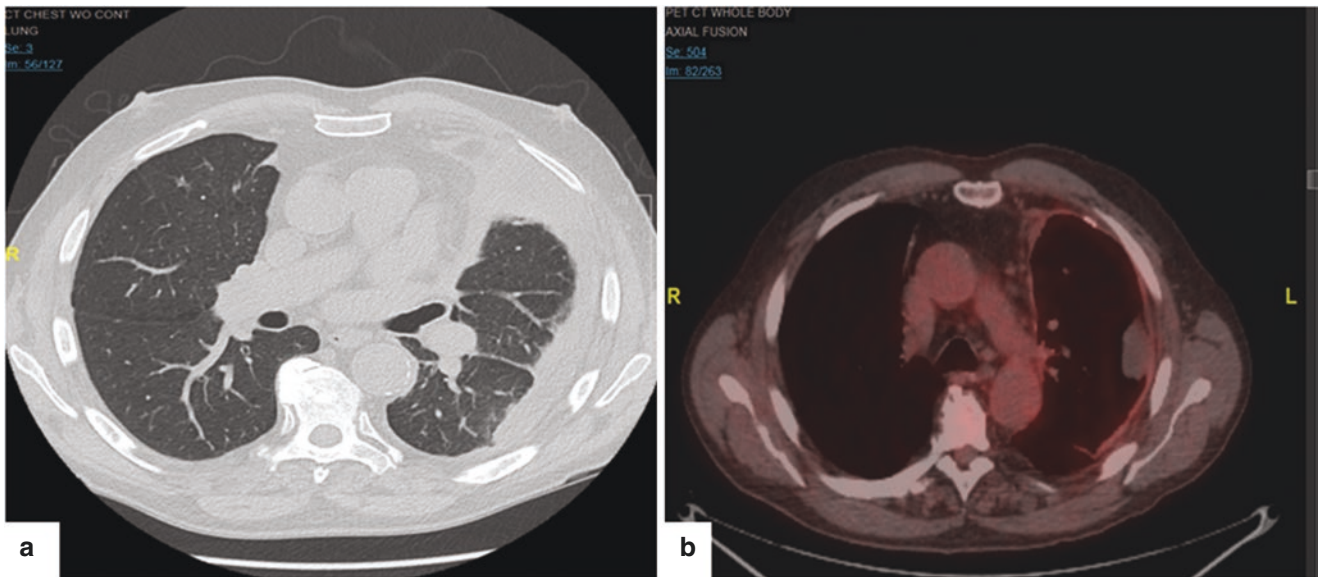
(a) Chest CT without contrast shows left pleural effusion and thickening. (b) PET-CT demonstrates mild abnormal FDG uptake within the pleura
